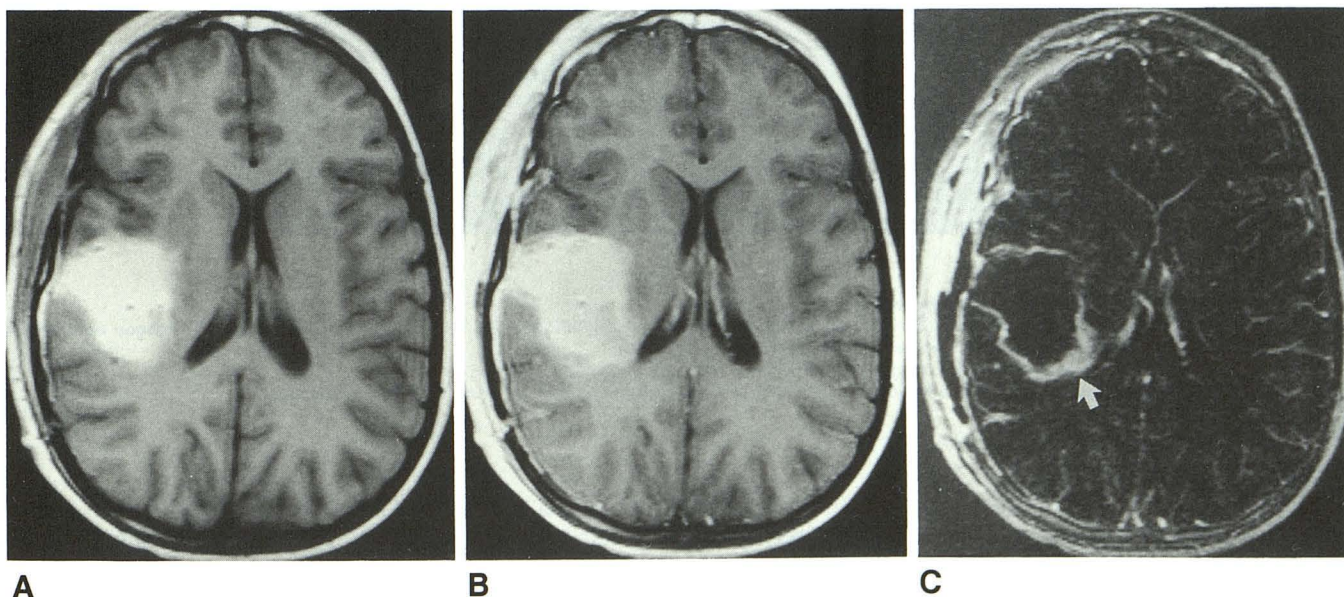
Postoperative MR images of a 10-year-old patient with right temporal glioblastoma multiforme.
